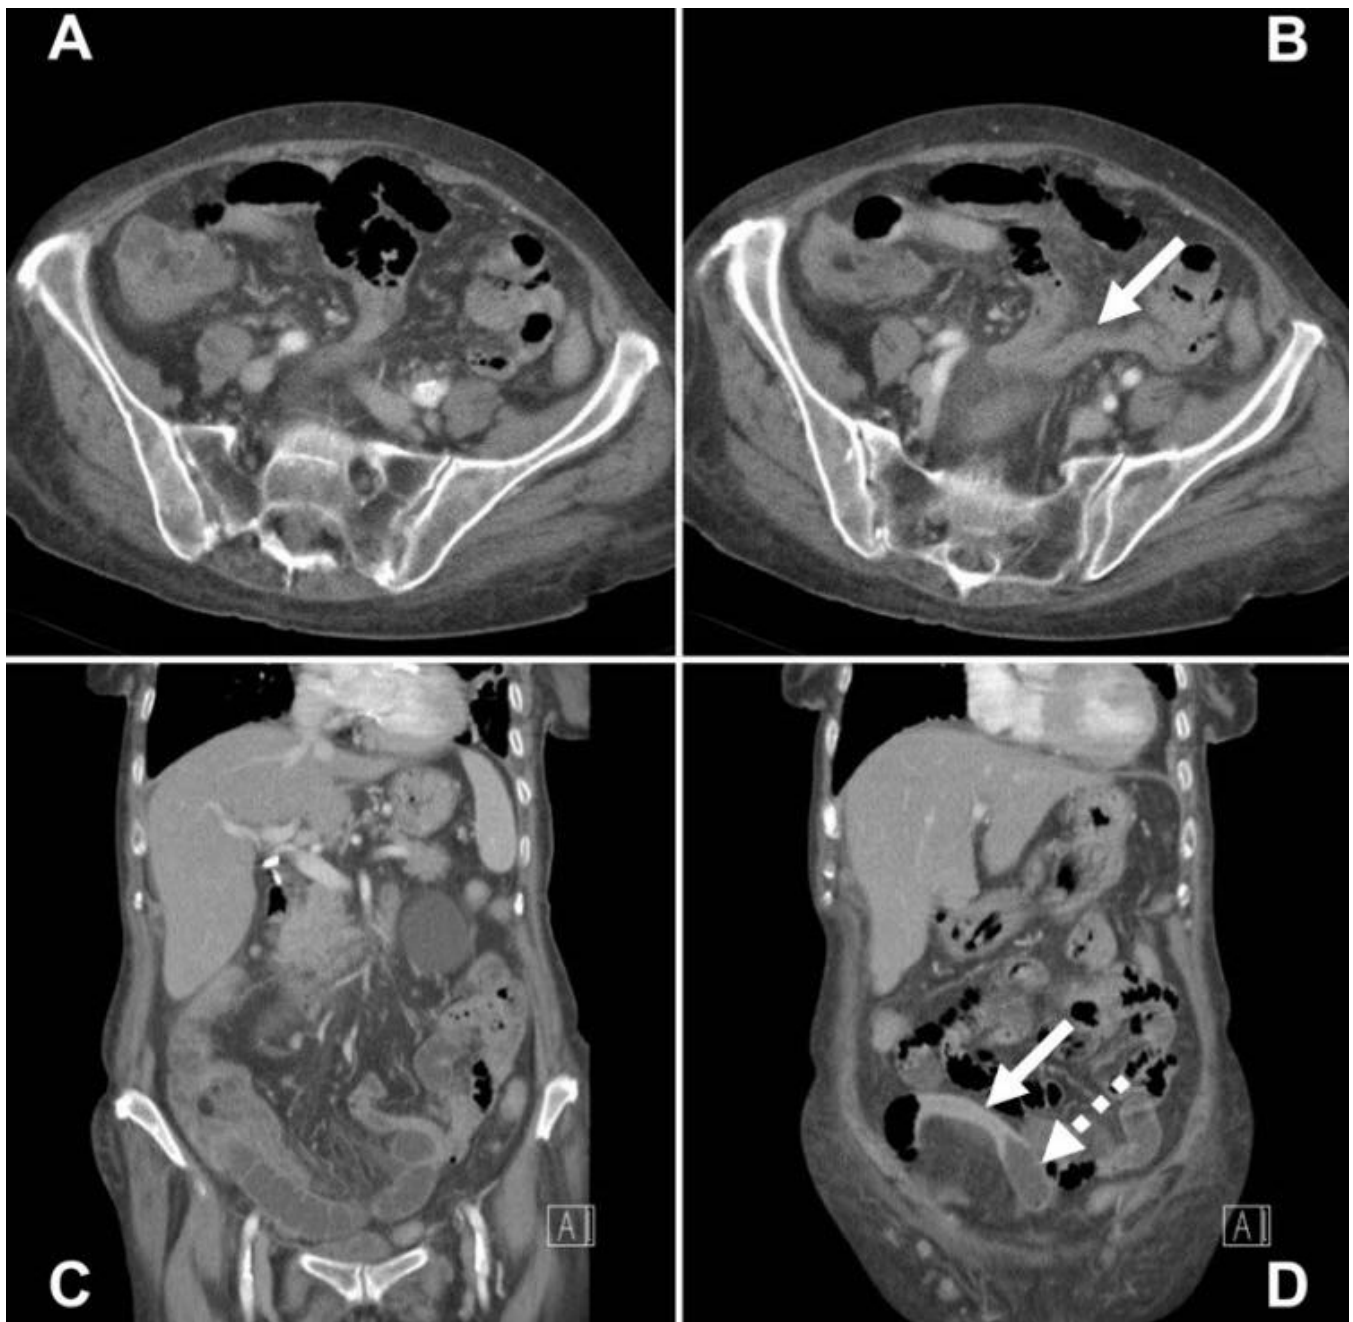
81 year old woman with gastrointestinal amyloidosis presenting as enterocolitis on abdominal CT scan. Axial (A and B) and coronal (C and D) multiplanar reformatted computed tomography images show wall thickening of several segments of the small intestine (arrow in B) with high grade stricture (arrow in D) and prestenotic dilations (dotted arrow in D).
